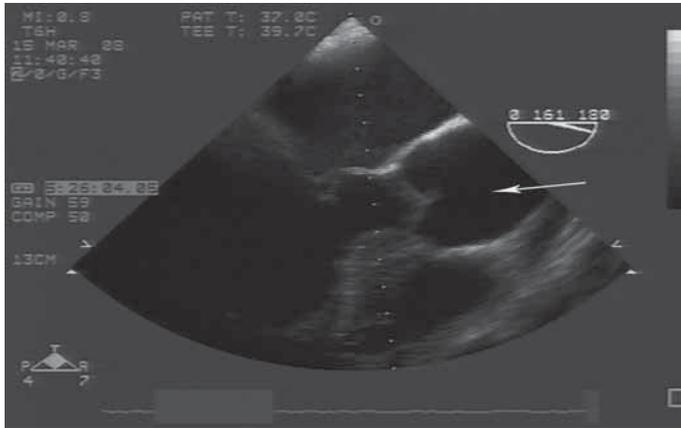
Transesophageal echocardiography, long-axis view, shows ascending aorta with no evidence of dissection. The arrow points to the ascending aorta Video 1. Transesophageal echocardiography, long-axis view, shows the motion image of ascending aorta with no evidence of dissection at different stages of cardiac cycle
